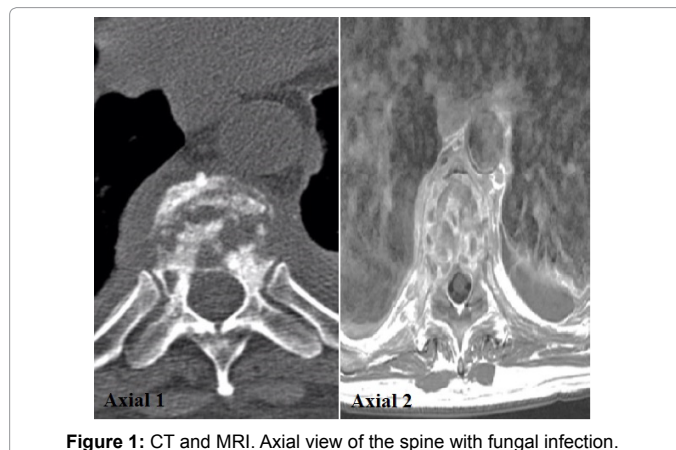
CT and MRI. Axial view of the spine with fungal infection.
